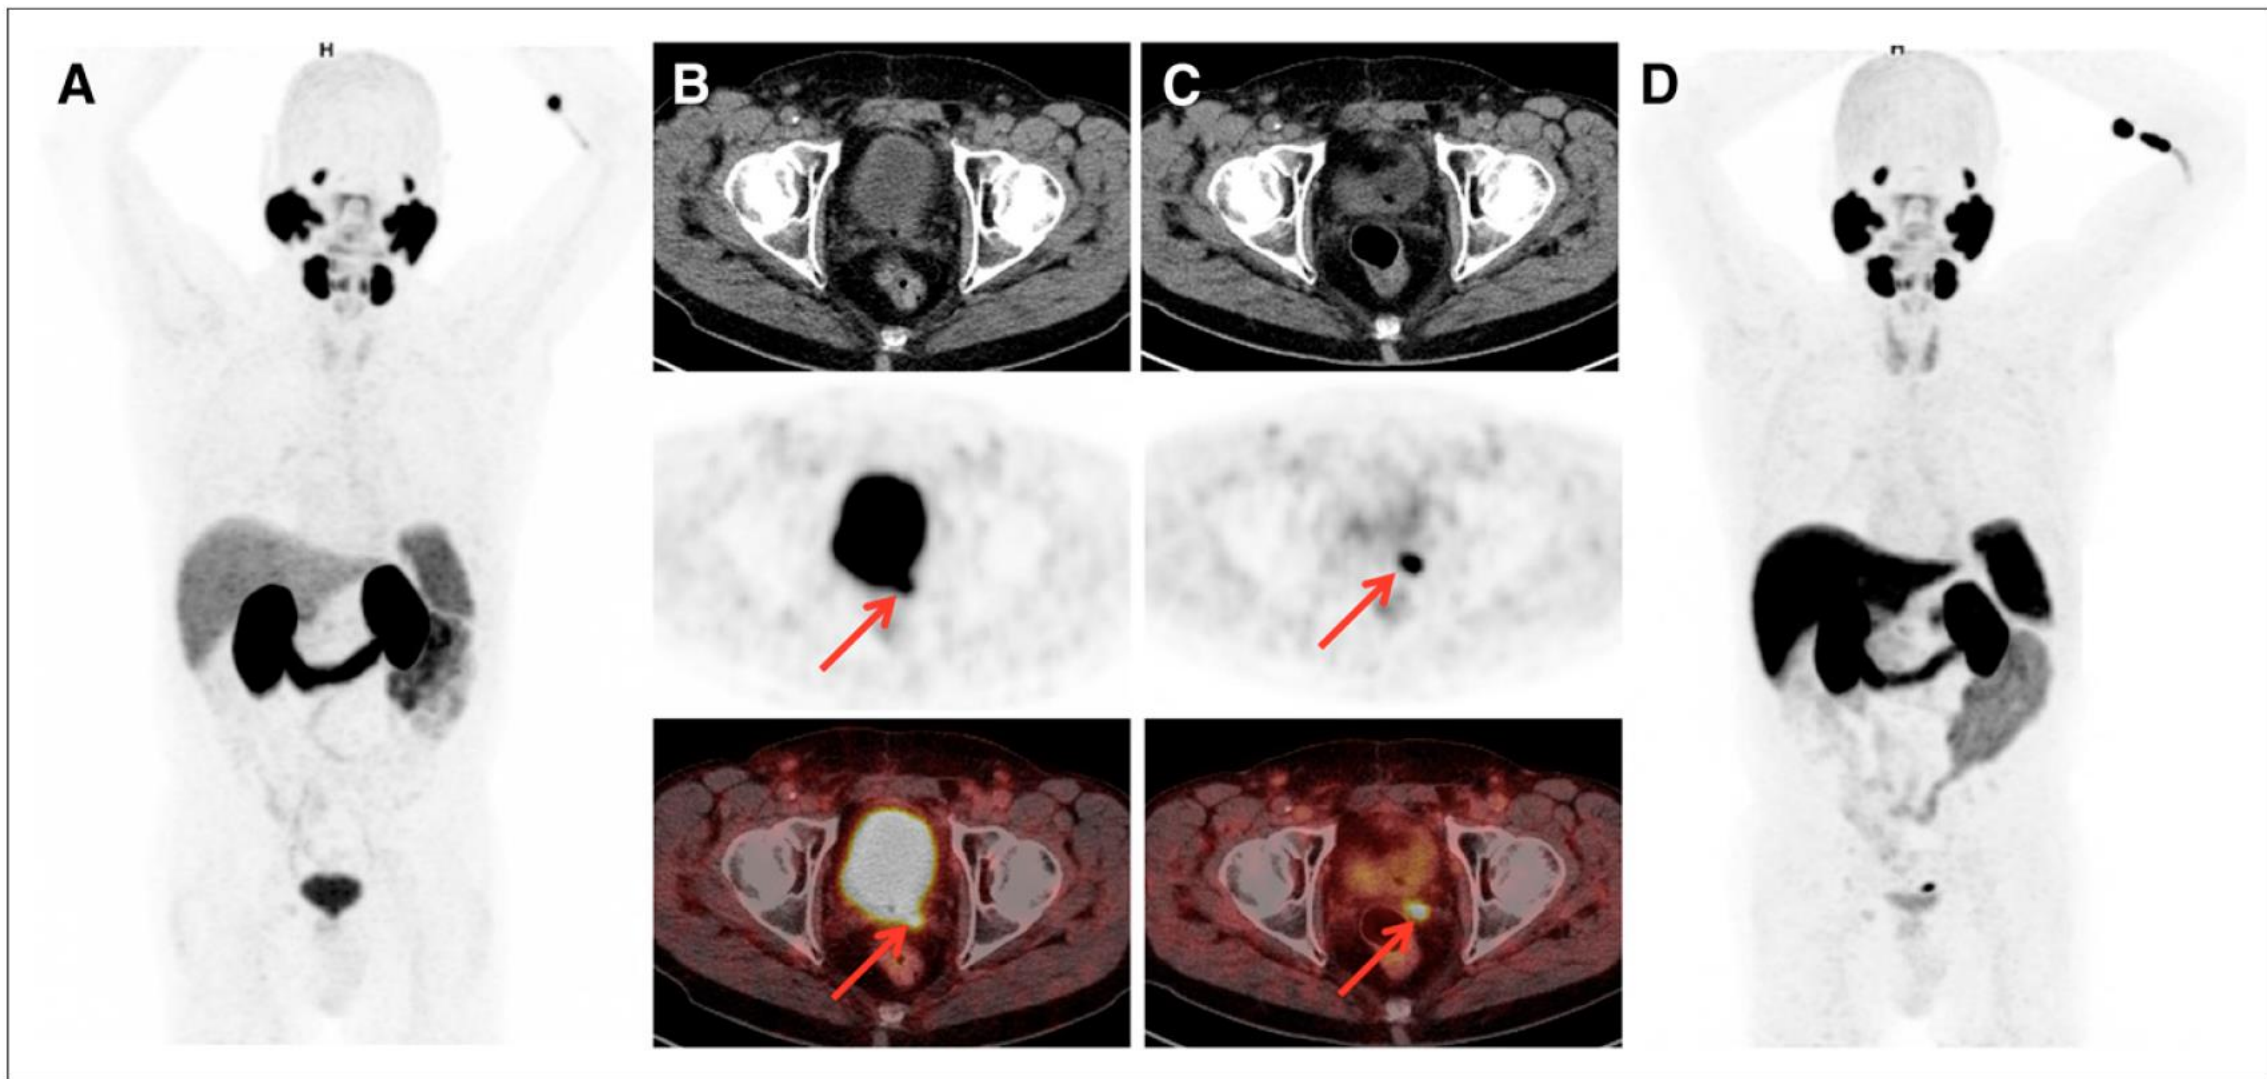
Images from 76-y-old patient after radical prostatectomy (2006; Gleason score of 7b; pT3a; pN0) and with PSA level slowly rising to 0.78 ng/mL (October 2017). (A and B) Patient underwent primarily ^{68}Ga -PSMA-11 PET/CT, which resulted in suggestion of local recurrence (arrows). No definite diagnosis could be made on basis of adjacent high activity retention in urinary bladder. (C and D) Subsequent ^{18}F -PSMA-1007 PET/CT 3 mo later clearly depicted PSMA ligand uptake in left seminal vesicle (arrows) with high contrast and very low retention in bladder.
